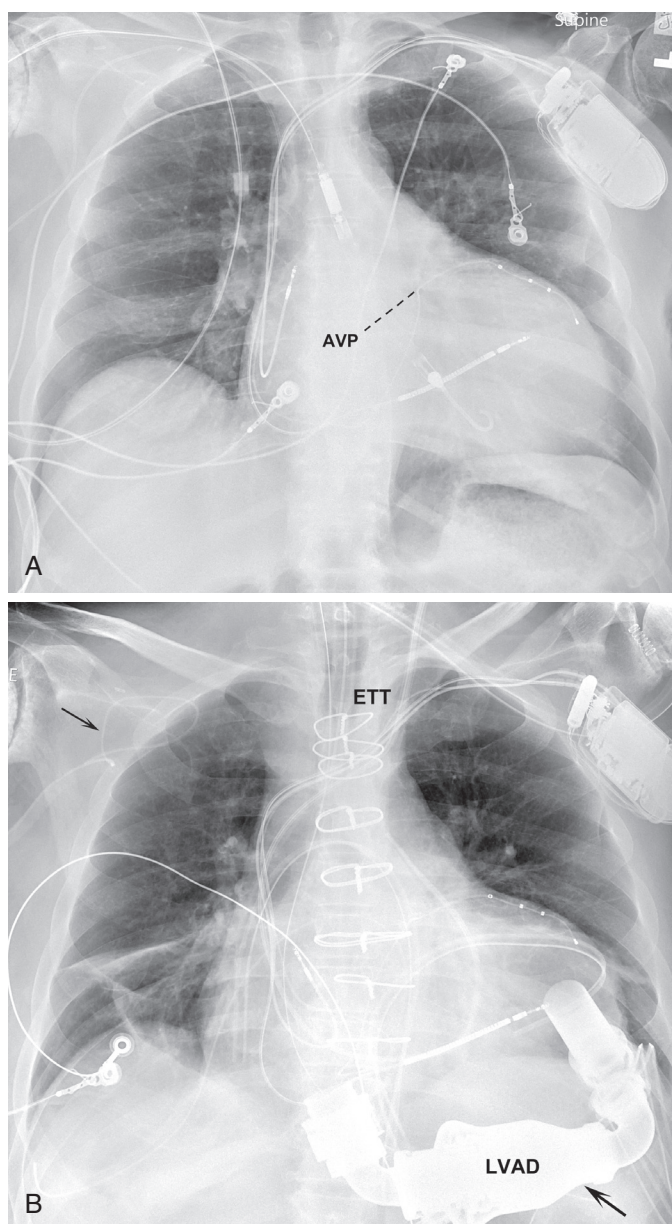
■ A, Anteroposterior (AP) supine chest x-ray. Impella device properly positioned, straddling the aortic valve plane (AVP). B, Anteroposterior (AP) upright chest x-ray. Same patient after undergoing surgery via a sternotomy to replace the impella with an LVAD (bottom right arrow). Right, PICC line now coiled at right axillary vein level (top left arrow). Cardiomegaly and bibasilar subsegmental atelectasis.
